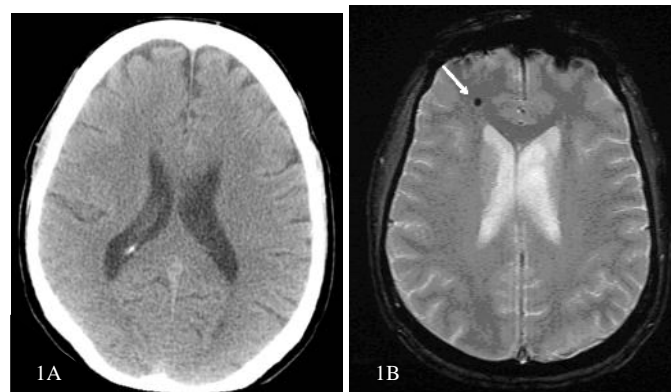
Non-Enhancing CT (NECT, A) fails to demonstrate an abnormality. MR Gradient Echo Image at the corresponding anatomic region (B) demonstrates a focus of low signal in the anterior radiations of the right frontal lobe (arrow). This focus represents hemosiderin deposition consistent with shearing injury or diffuse axonal injury.
